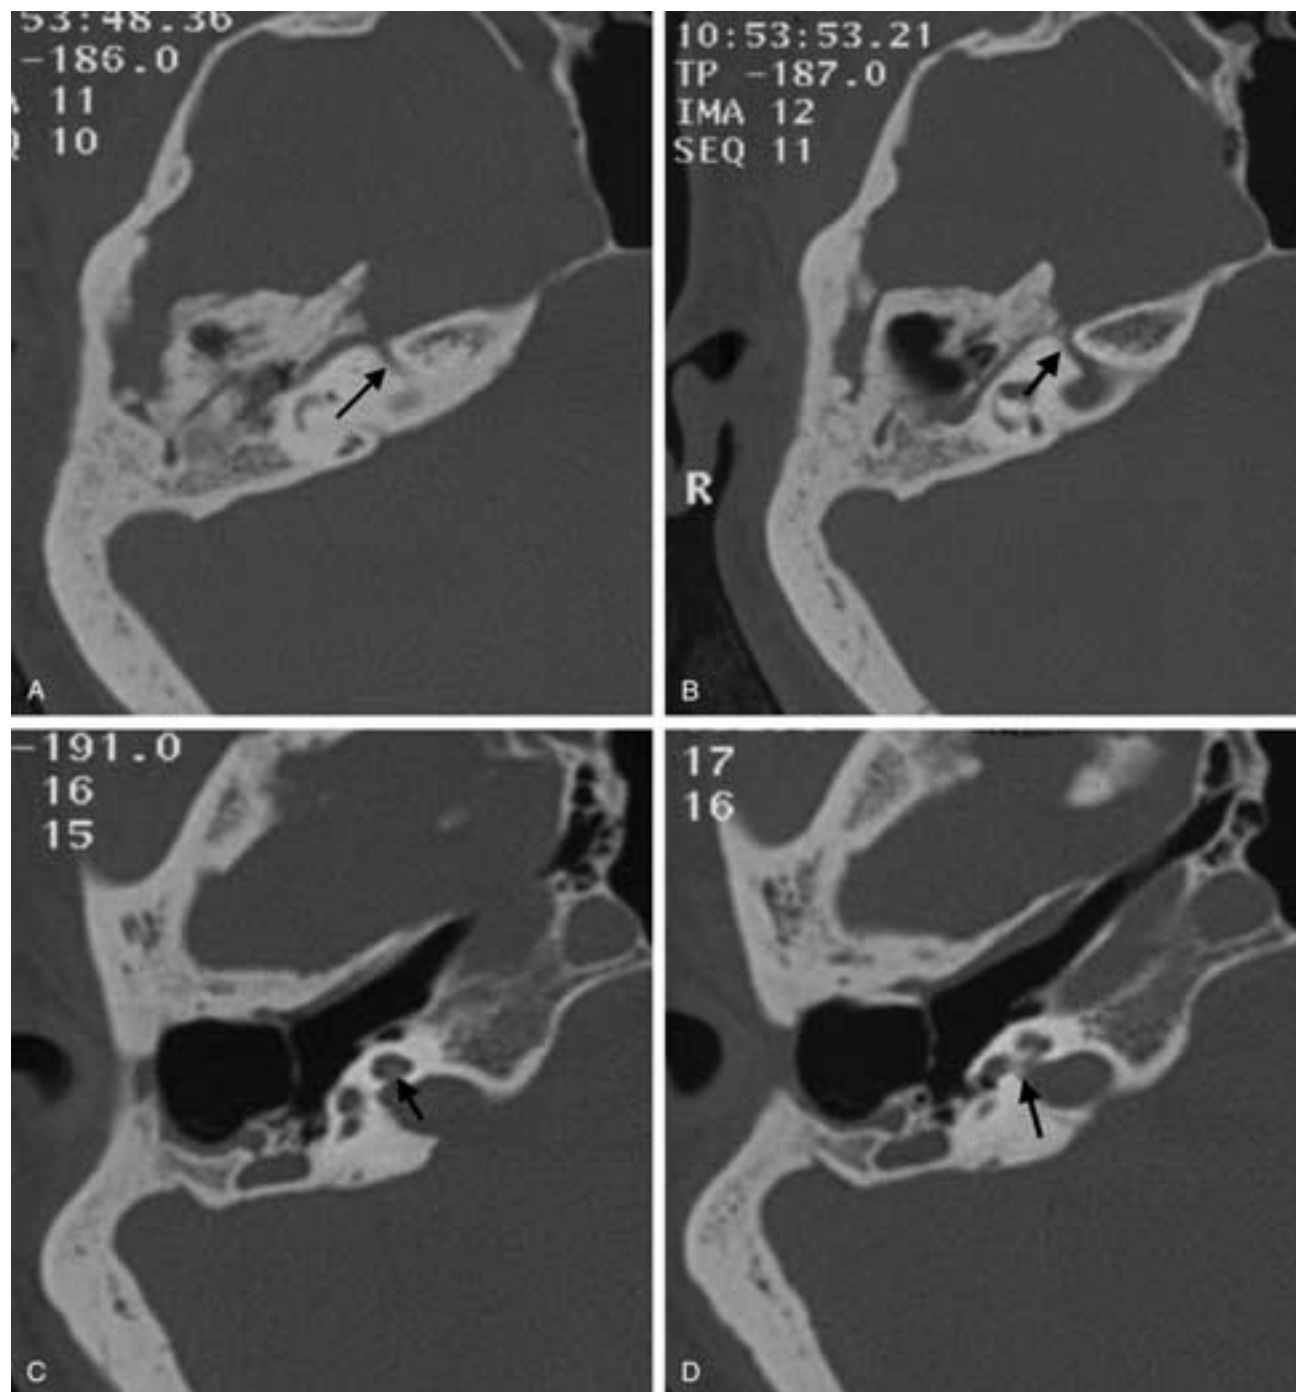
Hypoplastic (“dwarf”) cochlea and anterior migration of the facial nerve. A and B, Two contiguous 1 mm axial CT images showing anterior migration of the facial nerve canal (*black arrow*). C and D, Two contiguous axial CT images showing a hypoplastic cochlea (*black arrow*) with all three cochlear turns present but small: a dwarf cochlea.
